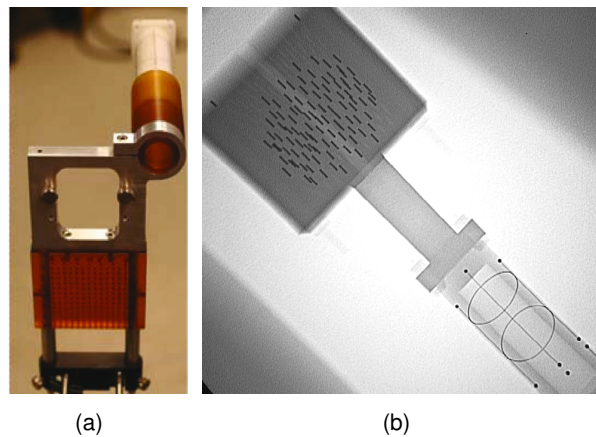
The FTRAC fiducial mounted over the seed insertion needle template using a mechanical connector (a). An X-ray image of the FTRAC fiducial including ellipses, ball bearings and lines (b).
